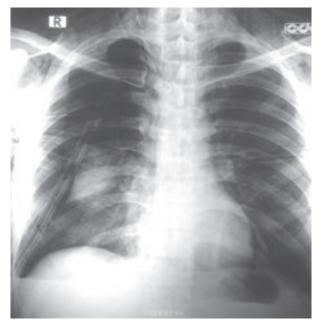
Chest radiograph showing heterogenous opacity occupying right hemithorax.
